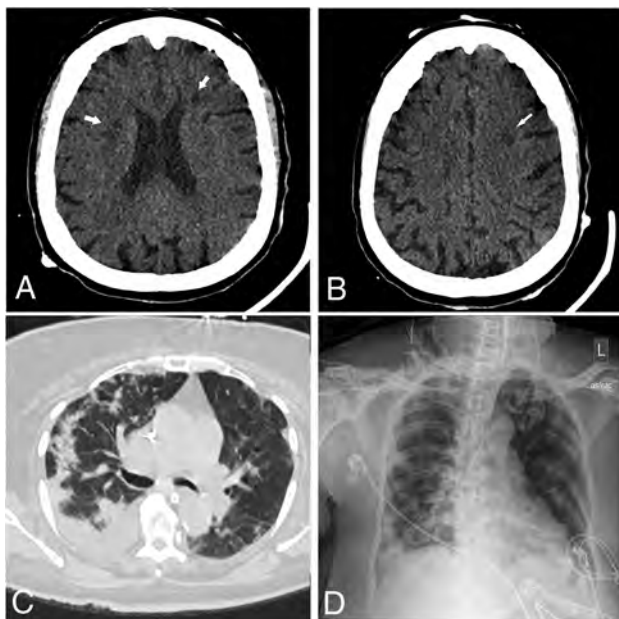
An 85-year-old man presented with increasing shortness of breath. Non-contrast-enhanced axial CT of the head demonstrates multiple new foci of hypodensity within the bilateral frontal corona radiata (arrows on A) and left centrum semiovale (arrow on B), in keeping with acute infarcts. C, Chest CT of the patient shows diffuse bilateral, right greater-than-left, predominantly consolidation and ground-glass opacities as well as bilateral pleural effusions. The CCS score was calculated as 13. D, Portable chest radiograph demonstrates bilateral patchy opacities with a PXS score of 10.6.
